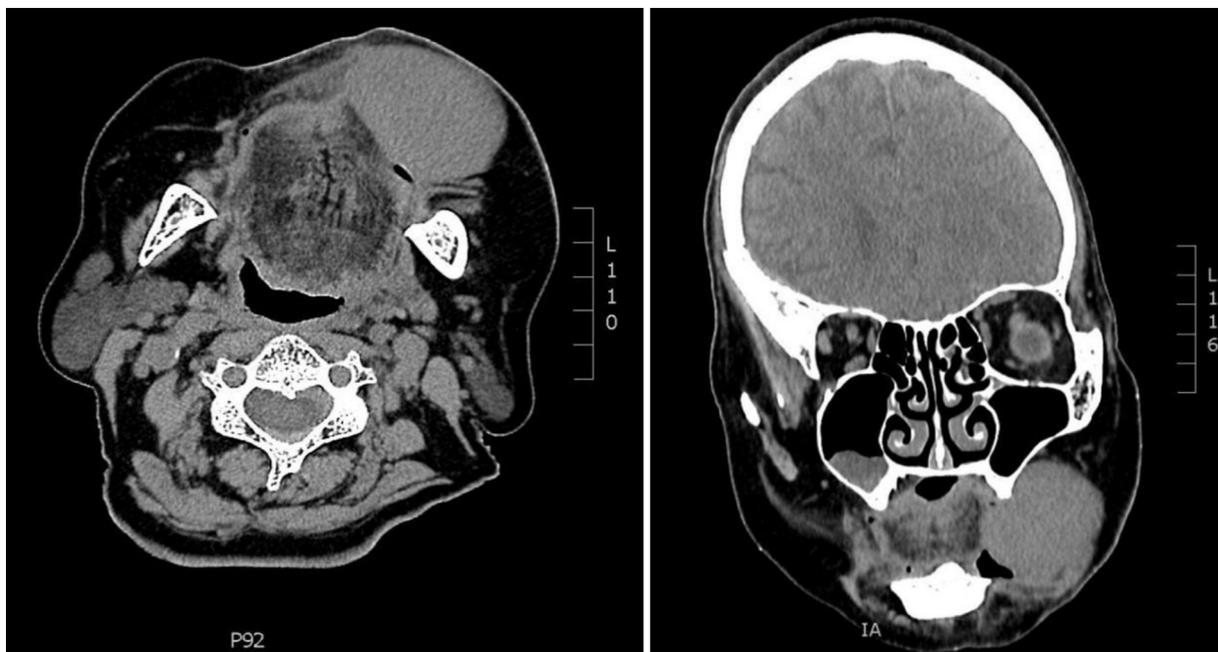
CT scan of the face with lymphoma of the left lip without bone lesion (axial and coronal slices).
